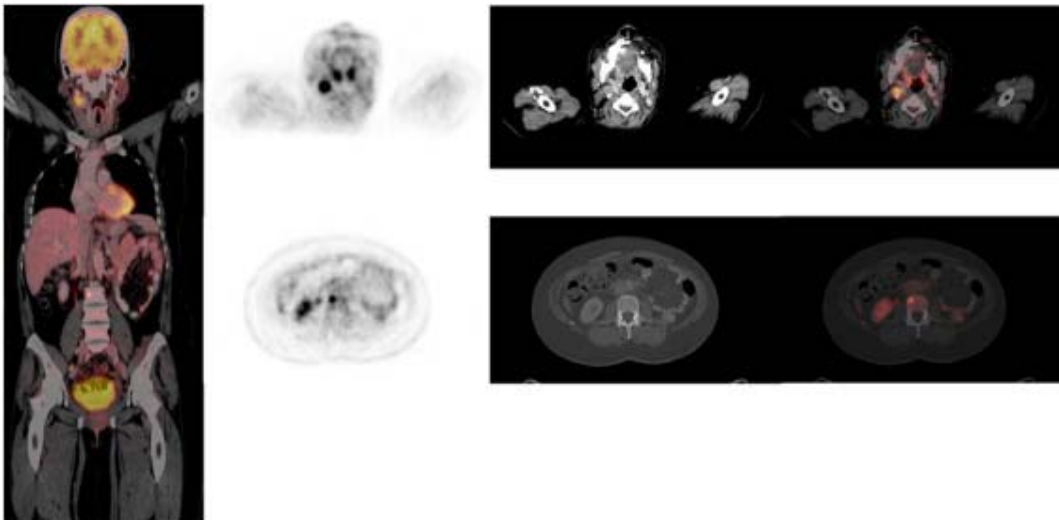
A 51-year-old female with a history of surgical resection of malignant melanoma from the uvula. FDG PET/CT obtained for re-staging showed right-sided cervical lymph node metastasis and a solitary skeletal metastasis to L3 lumbar vertebra.
